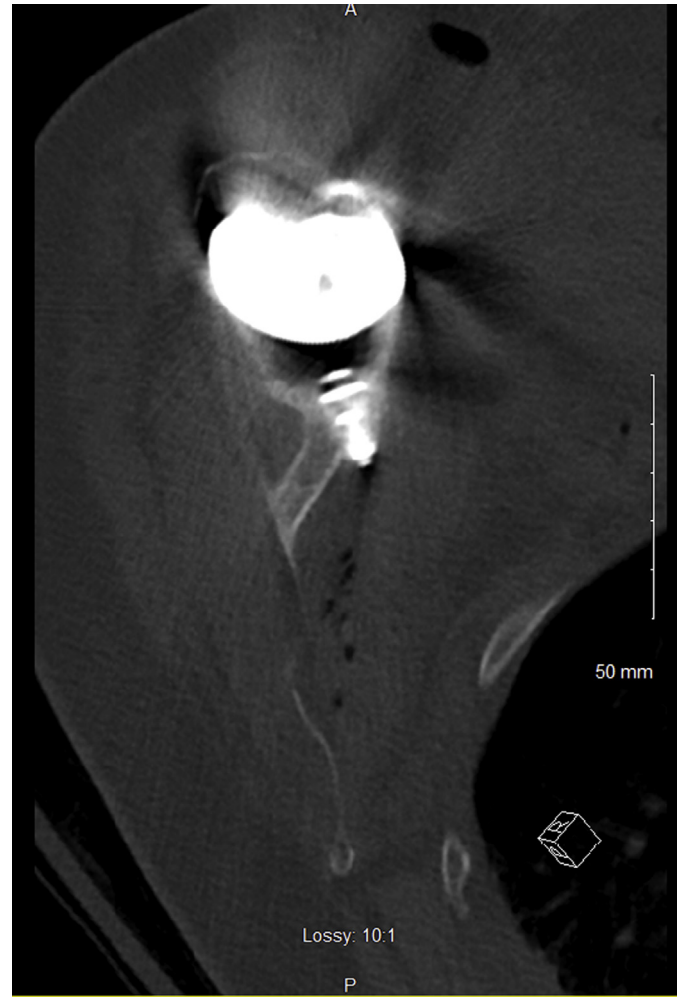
Axial computed tomography scan demonstrating Walch type C glenoid with central prosthetic glenoid peg transgressing anterior cortex (subsequent slices located it medial to coracoid base). A, anterior; P, posterior; R, right.
